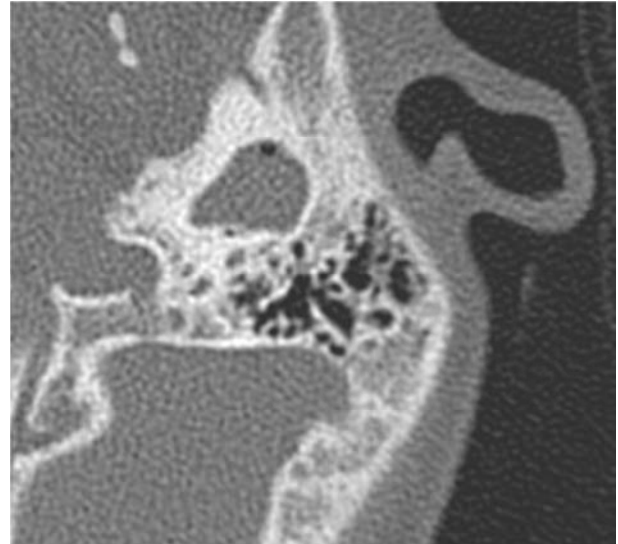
Axial CT Right Temporal Bone with evidence of ossicular erosion. There is a small portion of the malleus and incus remaining.
